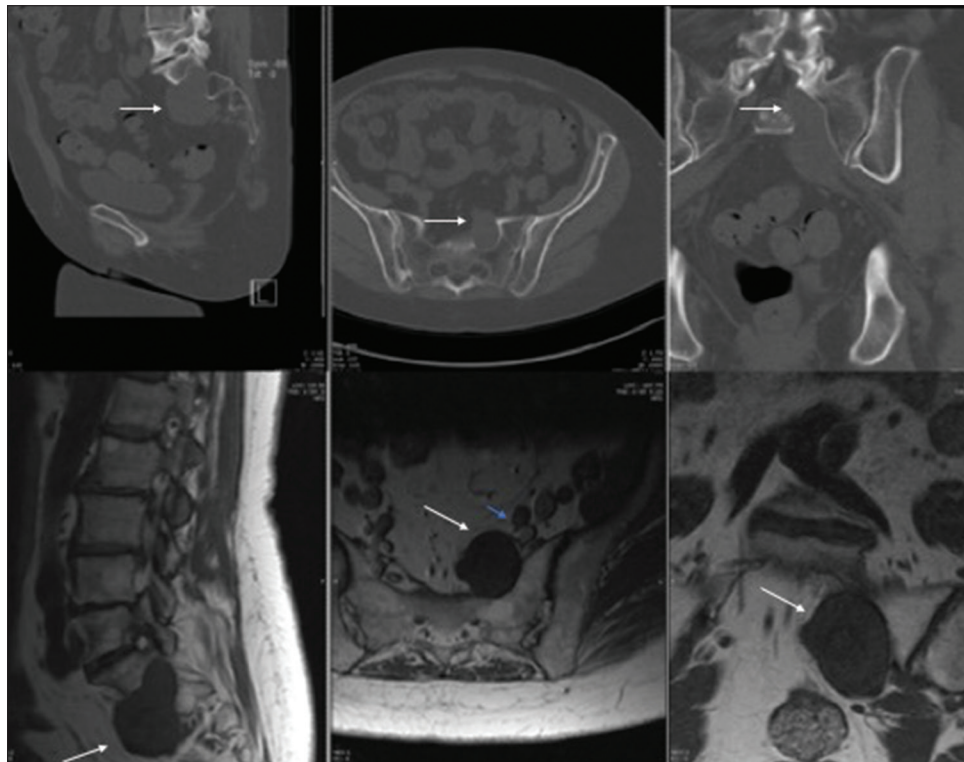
Preoperative non-contrast CT (top) and MR (bottom) sagittal, axial, and coronal images demonstrating a large presacral schwannoma (white arrow) extending from the left S1 neuroforamen. Axial MR image demonstrates close proximity of iliac vessels (short blue arrow).
